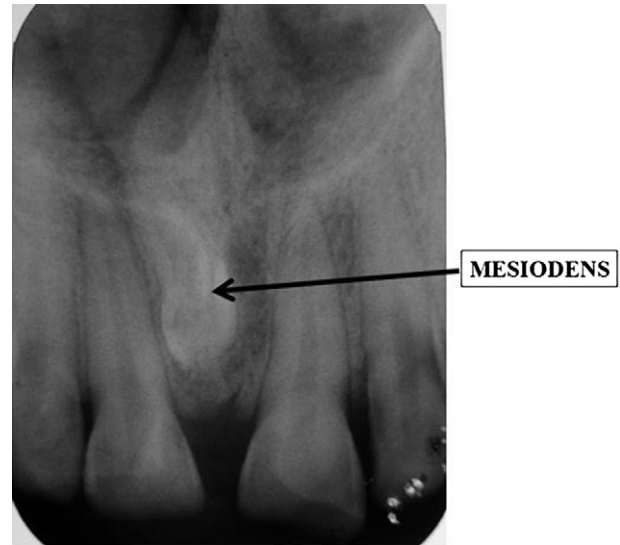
Intra oral periapical radiograph showing un-erupted mesiodens between roots of 11 & 21.
